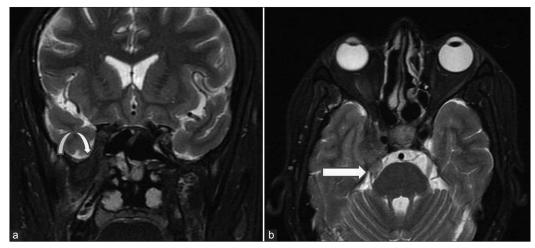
Fat-suppressed T2-weighted coronal (a) and axial (b) images show hypointense lesion extending from pterygopalatine fossa into middle cranial fossa through widened foramen rotundum (curved arrow). In middle cranial fossa, the lesion is seen in Meckel's cave and extends into prepontine segment of the right trigeminal nerve (long arrow)
